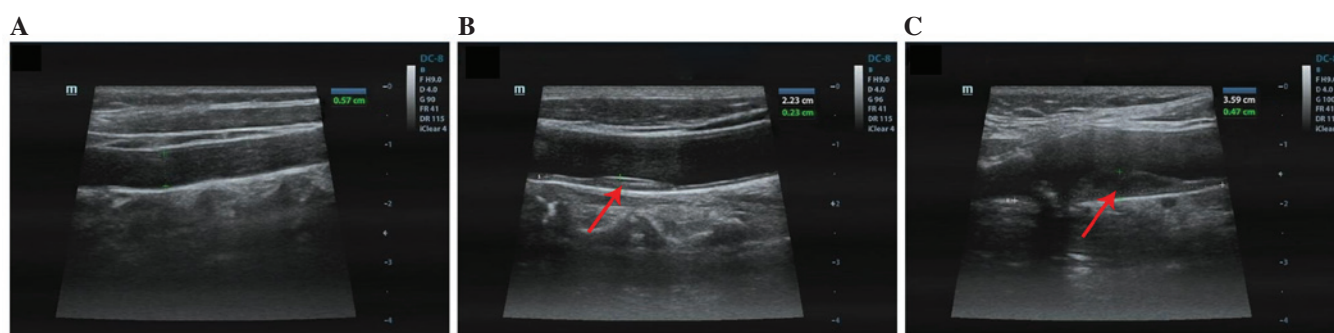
Carotid artery plaques detected by Doppler ultrasound. (A) Carotid artery in the healthy control group. (B) Carotid atherosclerosis plaque sonograms from patients with (B) minor (plaque area, 0.23x2.23 cm) and (C) severe (plaque area, 0.47x3.59 cm) lesions. Sonograms were performed on the right side of the carotid artery to atherosclerosis plaques. Plaques are demonstrated by the red arrows.
